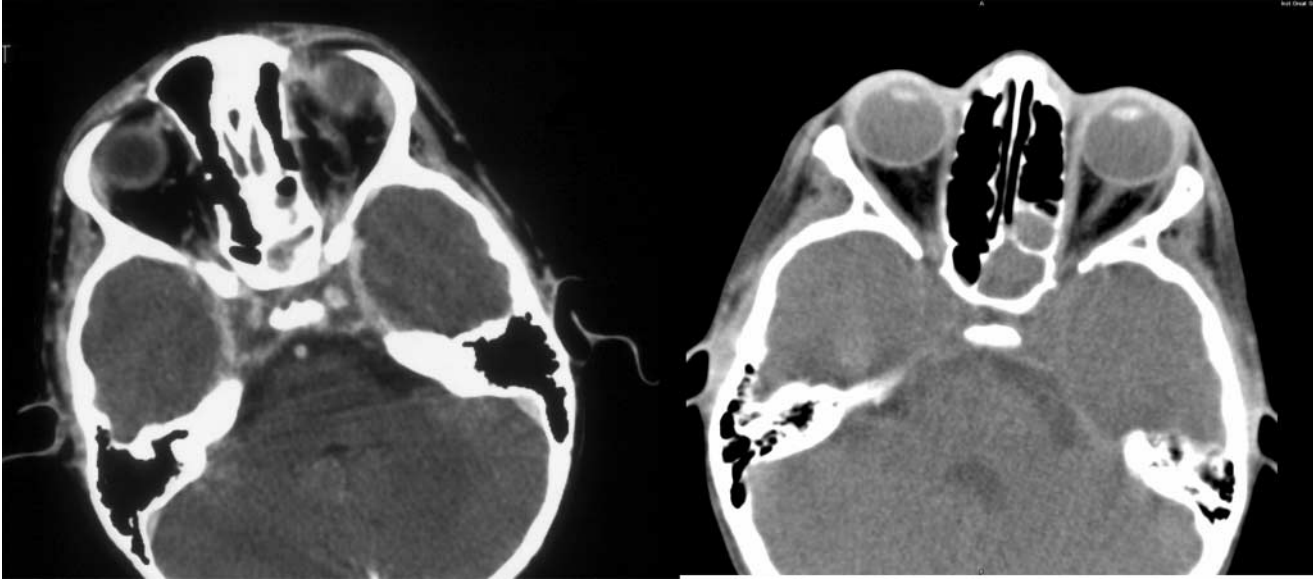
The post contrast computerized tomography (CT) scan on the left shows poor enhancement of the cavernous sinus bilaterally. The uncontrasted CT scan on the right shows subtle hypodensity in the region of the cavernous sinus. There is also associated opacification of the sphenoid sinus and posteriorly situated ethmoidal air cells
